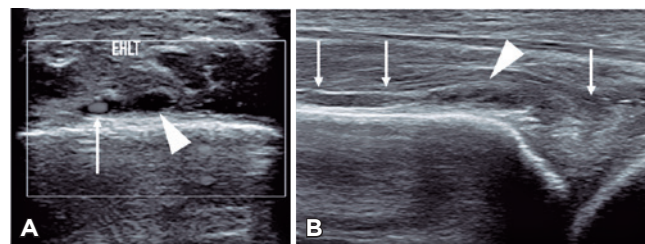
Ultrasonography showing a case of axonotmesis. A) Color Doppler axial plane. B) Color Doppler longitudinal plane. In axial plane, heterogeneous thrust of the deep peroneal nerve is observed in its course (arrowhead) adjacent to the anterior tibial artery (long white arrow), which can be recognized in the course of the nerve (white arrows).
